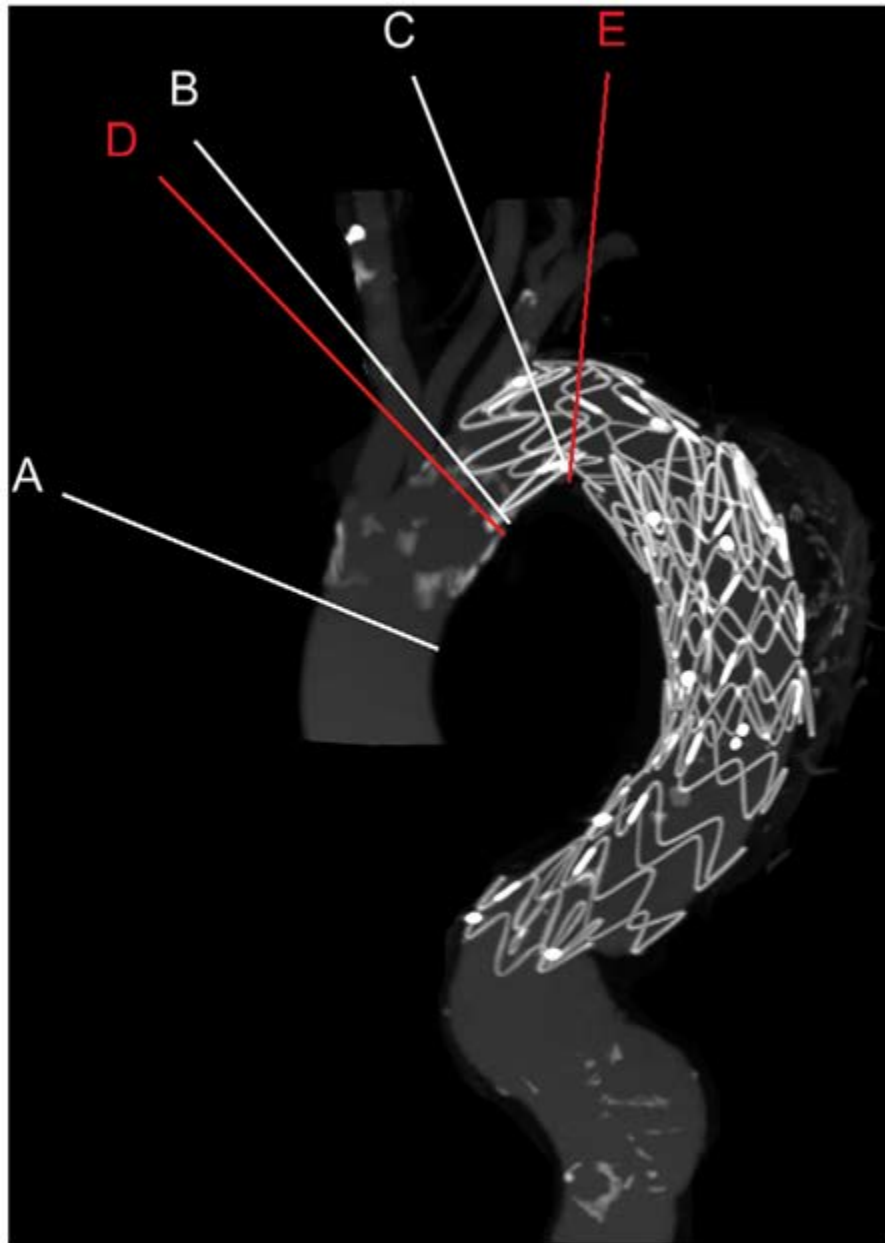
Anatomical levels. CTA maximum intensity projection reconstruction on which the levels studied are shown: 1 cm proximal to the innominate trunk (level A), 1 cm proximal (level B) and 1 cm distal (level C) to the left subclavian artery, and 1 cm proximal (level D) and 3 cm distal (level E) to the definitive proximal sealing zone. Levels in red depend on endograft position. Figure is taken from the work of van Prehn et al. (2009).
